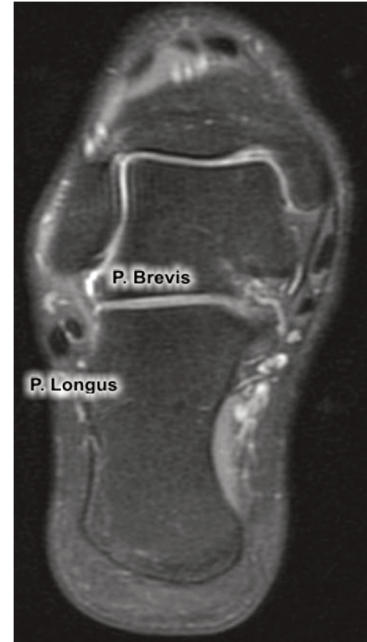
Coronal T2-weighted MRI.
